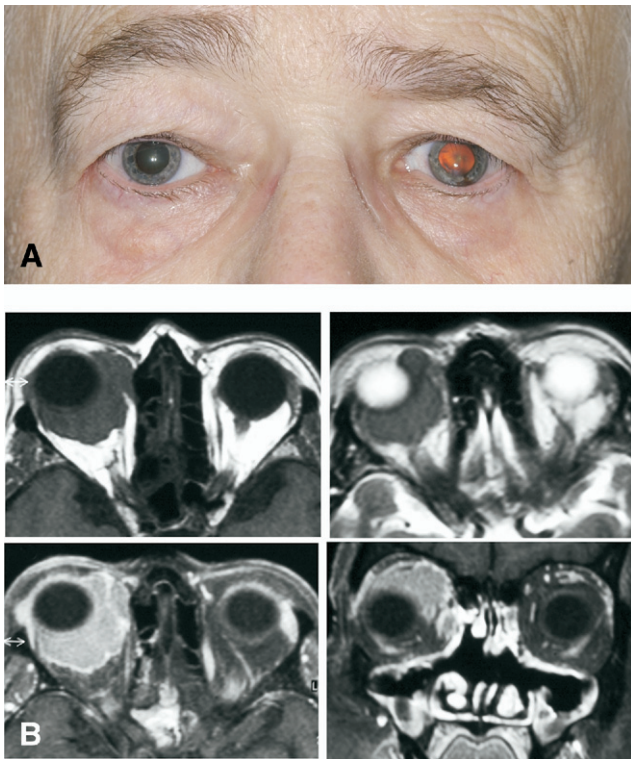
A, Photograph of a 75-year-old woman with left eye upper eyelid swelling and proptosis. B, Magnetic resonance imaging scans showing the orbital mass to be isointense to extraocular muscle on (upper left) T1-weighted images and (upper right) T2-weighted images and (bottom) showing intense contrast enhancement.
